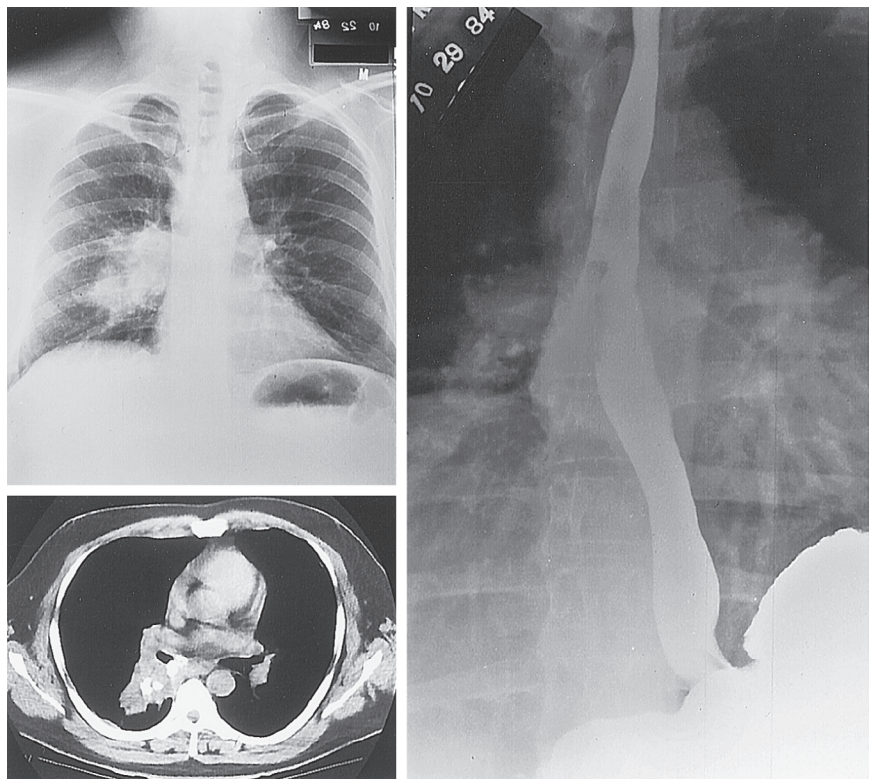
■ Computed tomography, contrast esophagography, and chest radiography demonstrating calcified mediastinal granulomatous disease secondary to histoplasmosis, with erosion into the adjacent esophagus.
